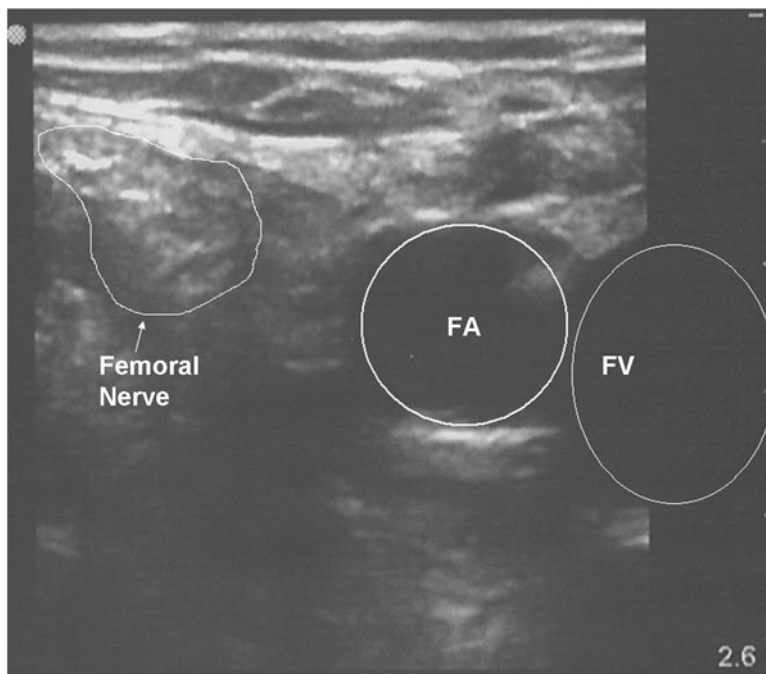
Ultrasound-guided femoral nerve block. Lateral to medial, the femoral nerve (FN), artery (FA), and vein (FV) are identified (*left* is lateral and *right* is medial)
